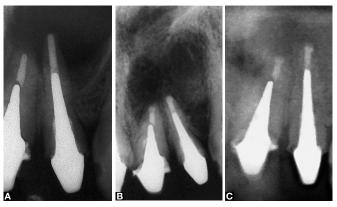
A) Preoperative radiograph B) Apicoectomy with MTA retrofilling on teeth 21 and 22 C) 1 year follow-up with periapical repair.
